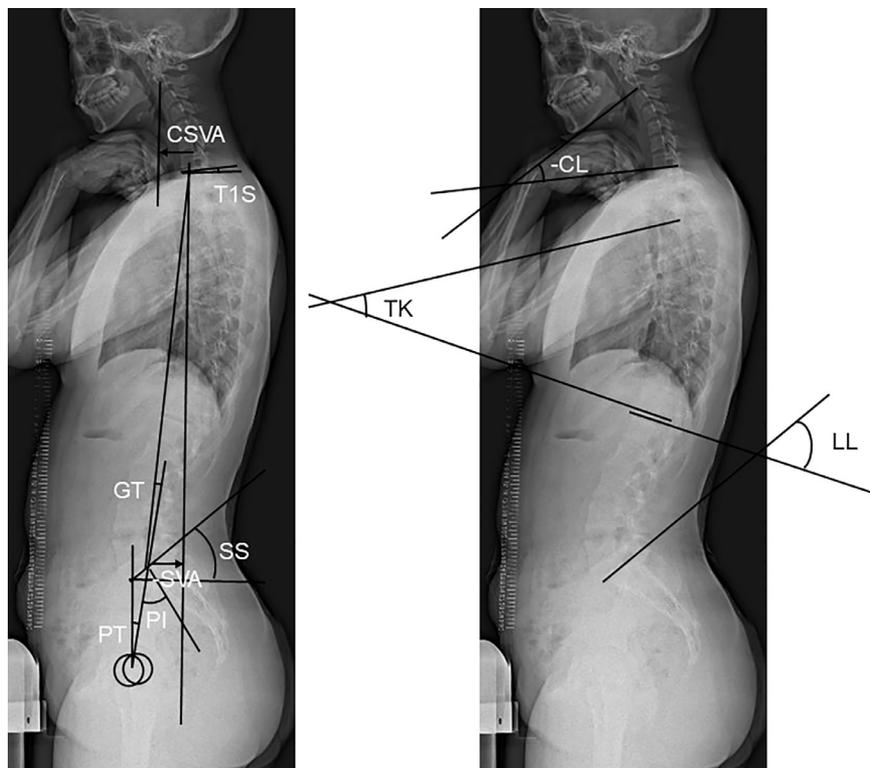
Radiographic parameters of sagittal spinal alignment.
